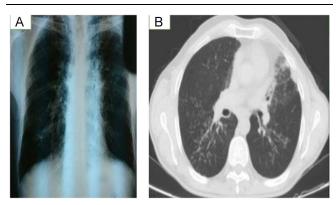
(A). X-ray demonstrated area of reticulation. (B). Ct scan shows bronchiectasis, high attenuation mucus plugging, tree-in-bud opacity and a little bit of ground glass opacity.
